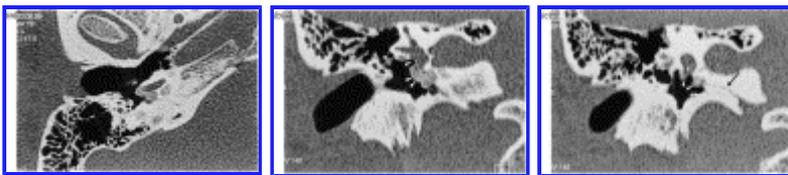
The round window niche. Axial plane HRCT. (a) Reconstructed coronal plane passing through the oval fossa (arrowhead). (b) More posteriorly reconstructed coronal (c) plane passing through the round window niche fossa (arrow). Stenosis of the round window niche and of the basal turn by hypodense osteosclerotic foci extending towards the cochlear aqueduct (arrowhead).
